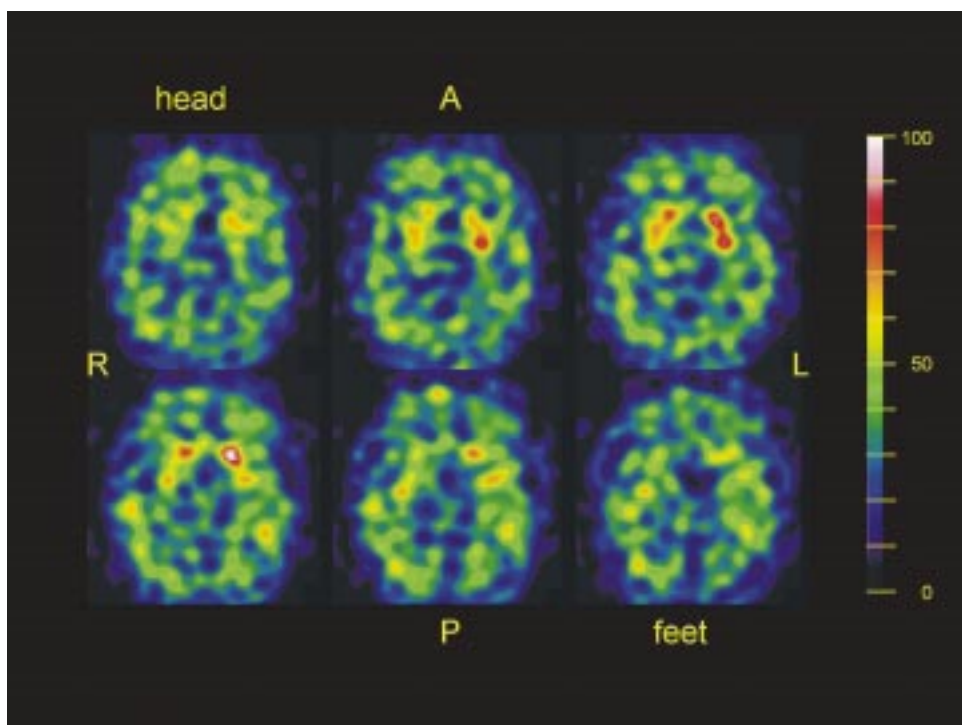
53-year-old patient with pronounced left-sided akinetic-rigid syndrome. SPECT images were obtained one hour after the application of 200 MBq ^{123}I -IBZM. Note the significantly reduced dopamine D_2 receptor density in the right striatum and in the left putamen, which is consistent with multiple-system-atrophy.
